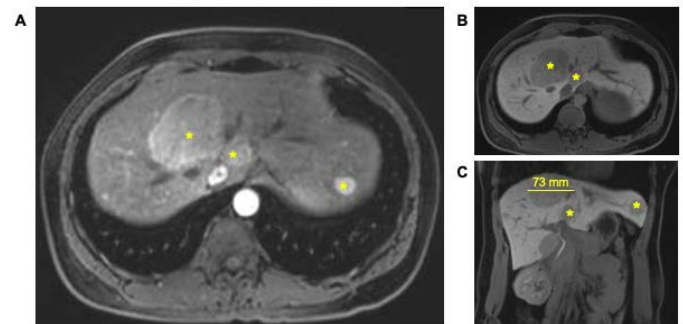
Multiple hepatic adenomas in a pregnant patient. (A) Using contrast enhanced MRI, T1-weighted arterial phase transverse image of the patient's multiple hepatic masses (*). Also shown are delayed, 18-20 min, T1-weighted transverse (B) and coronal (C) images with the largest lesion measuring 73 mm in greatest diameter.
